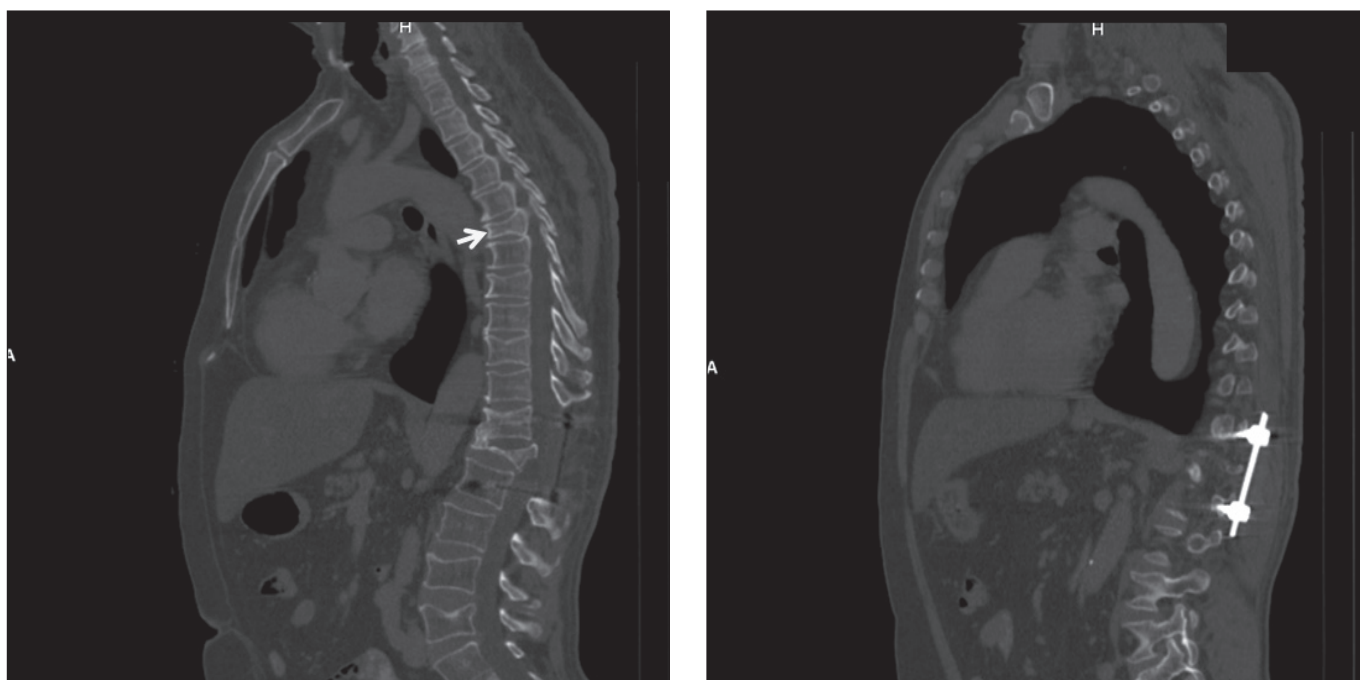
Computed tomography one year after the accident: T7 vertebral fracture (white arrow) and T12-L1 osteosynthesis material (sagittal plane).
